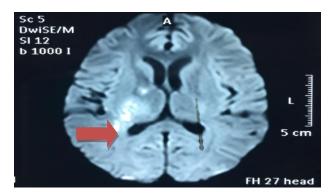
MRI Brain showing multiple acute infarcts in the right thalamus, capsular region and right periventricular region.
